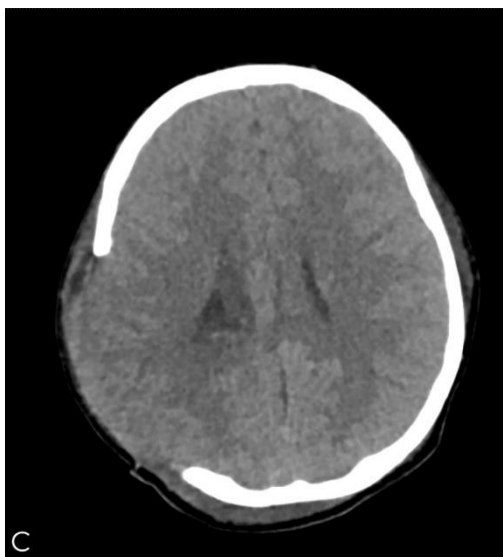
CT without contrast of the brain, after right parietal decompressive craniectomy and evacuation of the hematoma.
